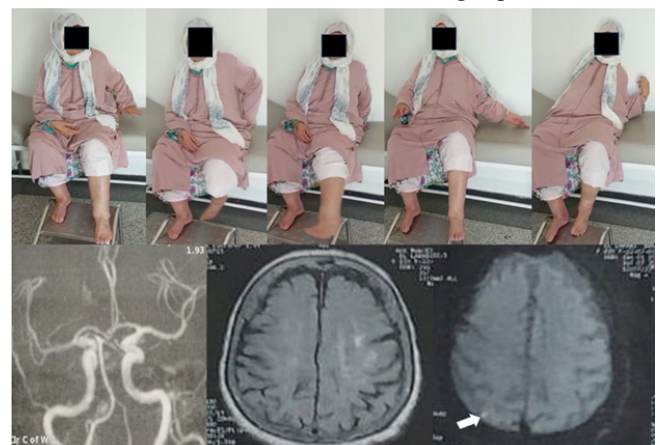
Clinical presentation of the patient with brain MRI showing a right parietal ischemic spot (arrow).
